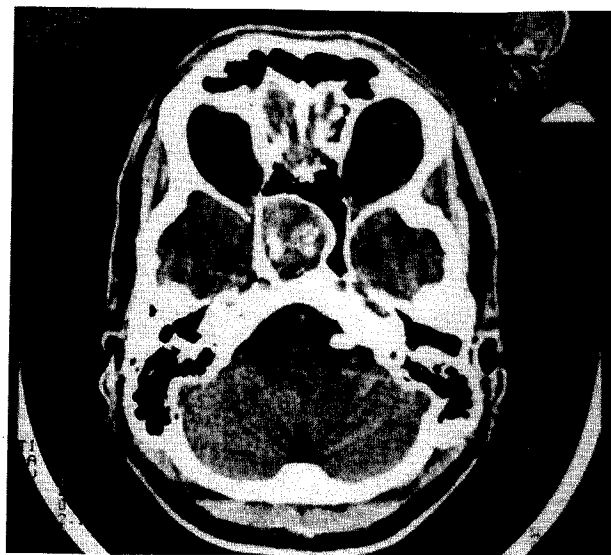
Enhanced axial computed tomogram of sphenoid sinus showing sclerosis and emphasized expansion of right sphenoid sinus. Surrounding bony structures seem to be of normal appearance. Computed tomography appearance of sinus content is characterized by heterogeneous density (ground-glass appearance). Isolated, bone-like particles of irregular, bizarre shape inside involved sinus not only closely resembled osteosarcoma's spicules, but also suggested aspergilloma.
